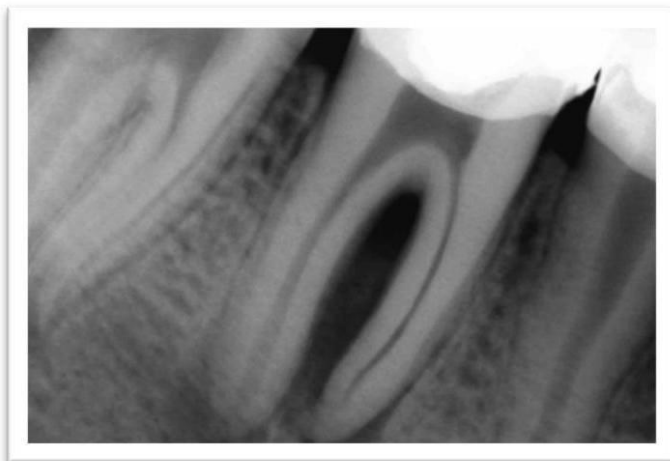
Intraoral periapical radiograph depicting periapical periodontitis with bifurcation involvement of the mandibular first molar. Image adapted from (HOUB)
